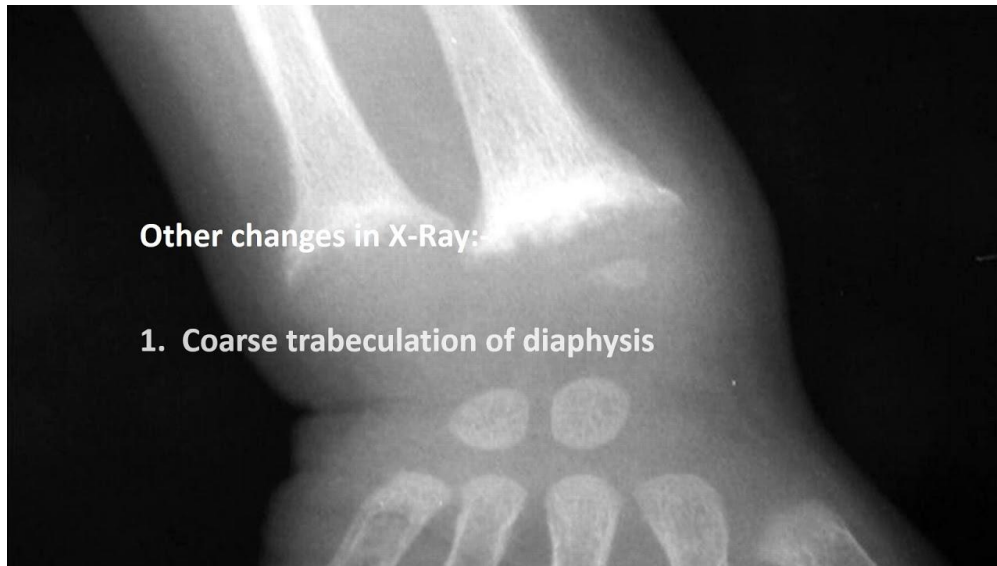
Radiographic changes and clinical manifestation in bones (in distal metaphysis of radius and ulna as well as distal metaphysis on tibia and fibula) were characteristic of rickets in our case.
